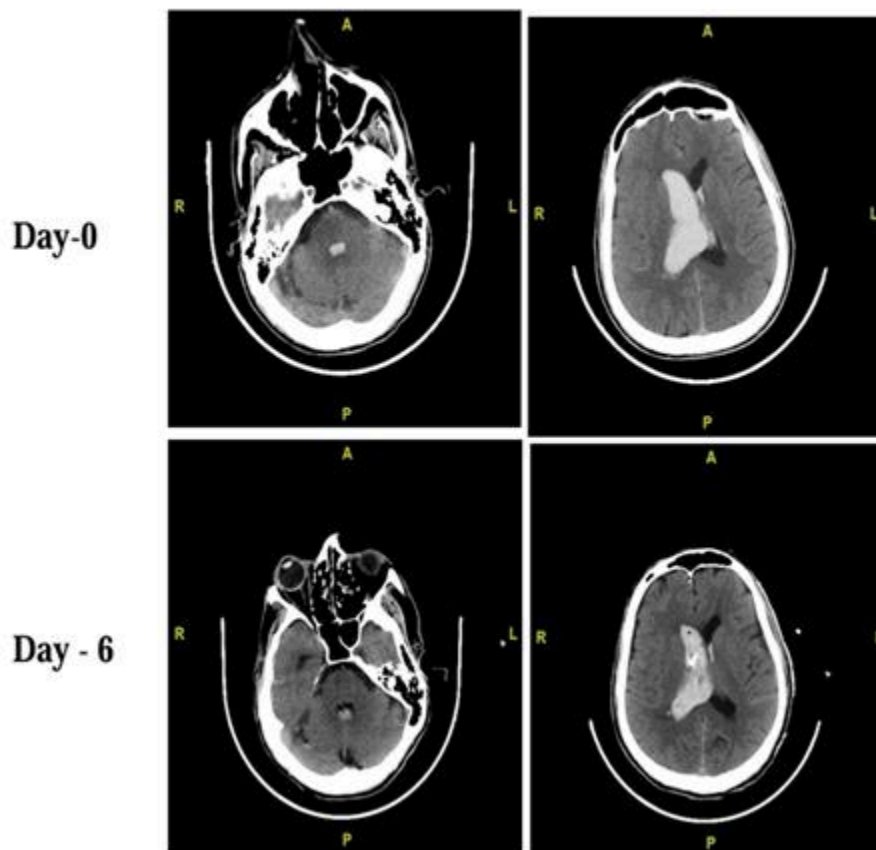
Non contrast CT of Primary IVH which was treated with EVD alone and the grab et al. score remains the same -7 even after 6 days of EVD
